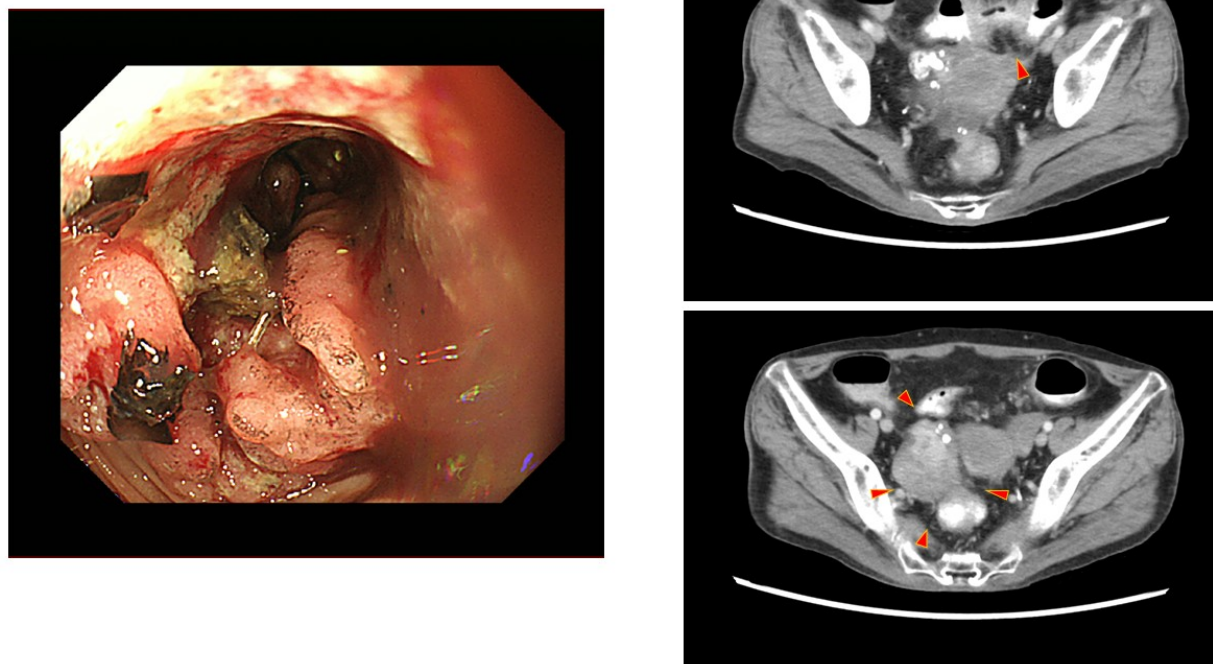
Colonoscopy showed an ulcerative tumor in the sigmoid colon (left). Computed tomography revealed wall thickening in the sigmoid colon (right, upper) and an irregularly shaped mass in the right ovary (right, lower).
